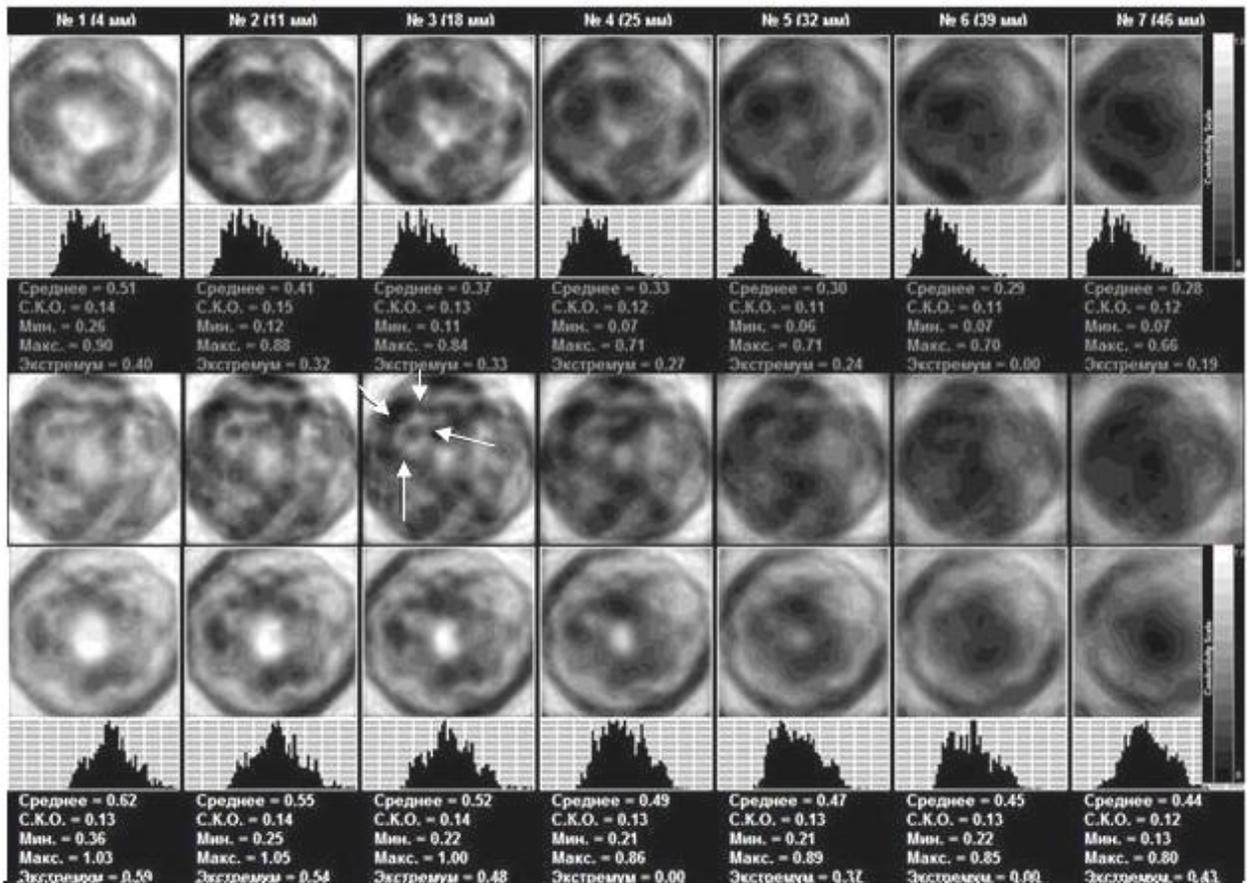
EIM. Top row – left gland. Mixed type of mammary gland structure. Hyper-impedance contour and background. The middle row represents the upper-outer segment of the left gland. At 10 o’clock position there is an irregular-shaped iso-impedance formation measuring 37x27 mm with a hyper-impedance contour. Lower row – right gland. Mixed type of mammary gland structure. ULTRASOUND: In the upper-outer segment of the left gland there is a steady formation without distinct contours 35x37 mm in size (oedema, infiltration)..
